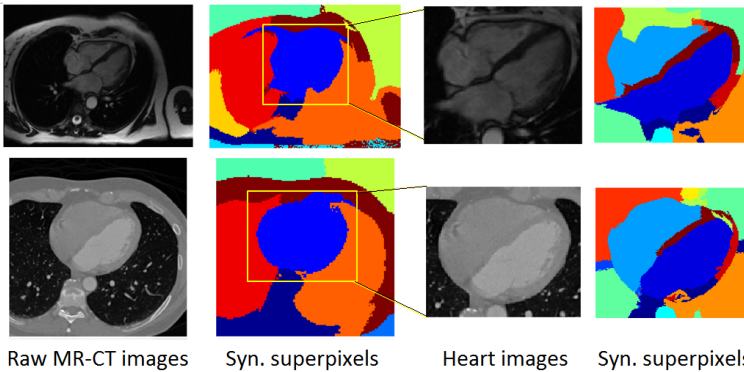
The simultaneous heart localization in raw axial MR-CT images using hierarchical SSN decomposition. Left to right: the raw axial images; the synchronized superpixels of the raw images; the heart ROI identified from the synchronized superpixels; the scale 2 synchronized superpixels for the heart images.
